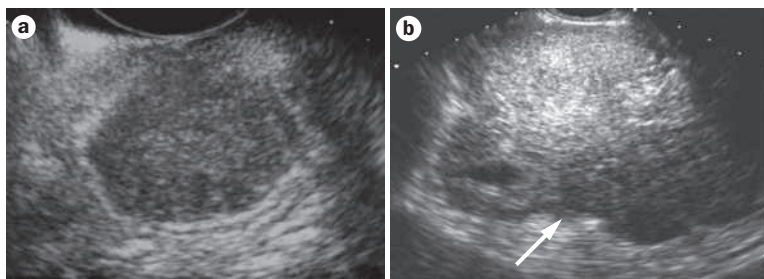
Endoscopic ultrasonography images of gastrointestinal stromal cell tumors. a | The classic findings of a round, hypoechoic mass, located in the fourth sonographic layer. b | The high-risk features of a large mass with irregular borders (arrow).
